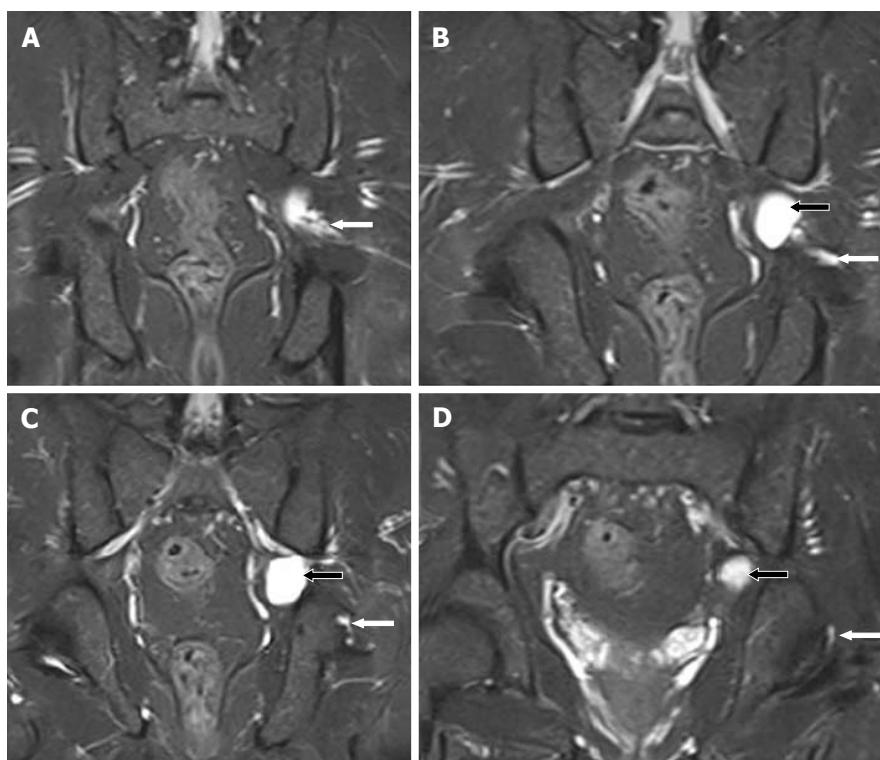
Images A-D show serial, T2-weighted fat suppressed coronal sections of the pelvis, demonstrate a cyst (black arrows) at the level of the left sciatic notch. The cyst extends along the articular branch of the sciatic nerve (white arrows) and communicates with the posteromedial aspect of the ipsilateral hip joint (D). No obvious labral or capsular tear or degeneration of joint is noted.
